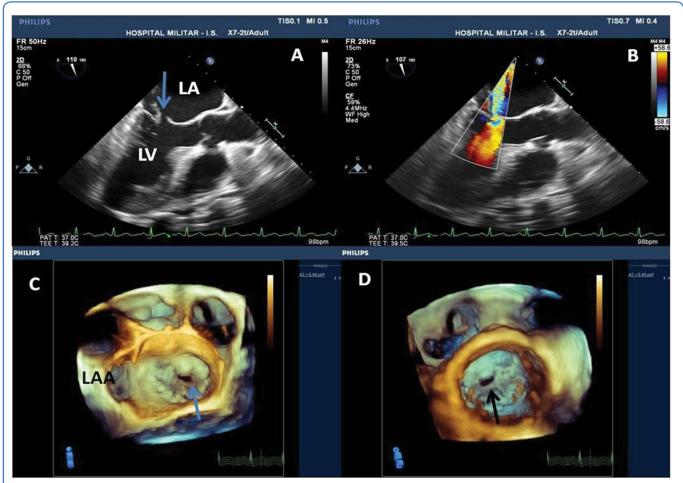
(A) 2-Dimensional transesophageal echocardiography revealed contiguity solution of the anterior leaflet of the mitral valve; (B) Doppler color study showing severe mitral regurgitation through the perforation; (C and D) Real time 3-Dimensional transesophageal echocardiography revealing the anterior leaflet of the mitral valve perforation in A2-A3 scallops; "en face" view from the left atrium and the left ventricle respectively. LAA - Left Atrial Apenddage; LA - left atrium; Ao - Aorta: LV - left ventricle.
